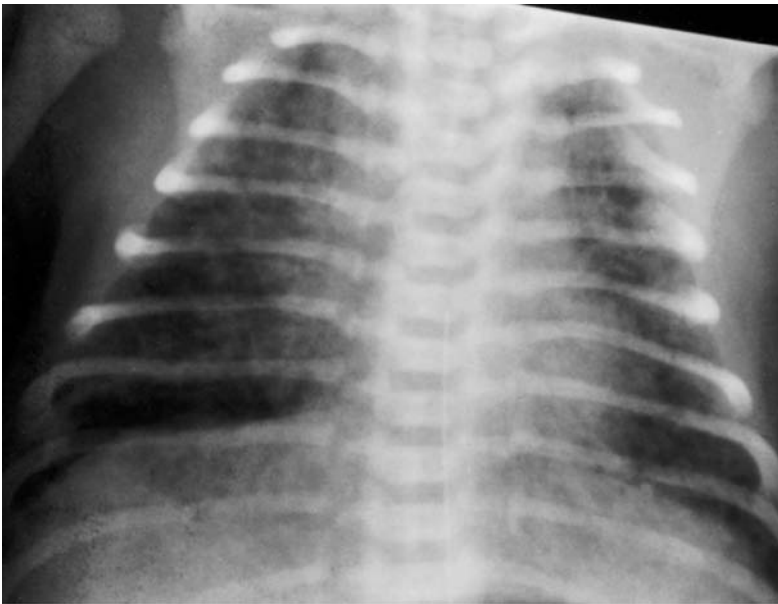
Meconium aspiration radiograph.
